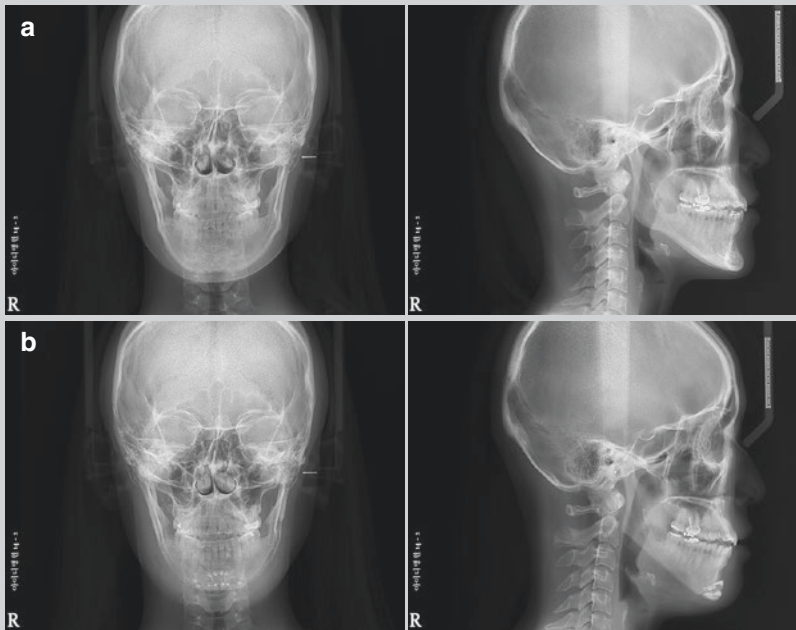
Case 1. Preoperative (a) and postoperative (b) radiographs showing length reduction and improvement of prognathism
